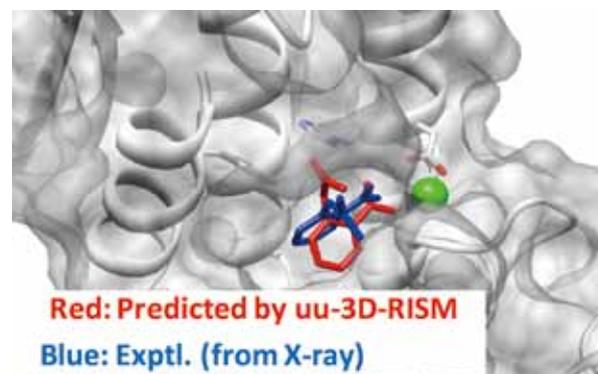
Predicted binding-mode of aspirin, which is obtained from uu-3D-RISM. The binding-mode determined by X-ray structure is depicted with blue sticks.
